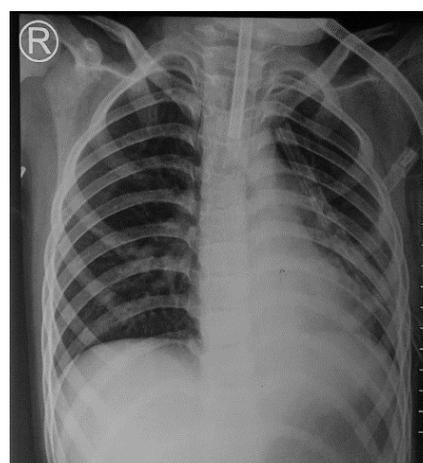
Thorax X-ray (anteroposterior view) after bronchoscopy and thoracotomy.
